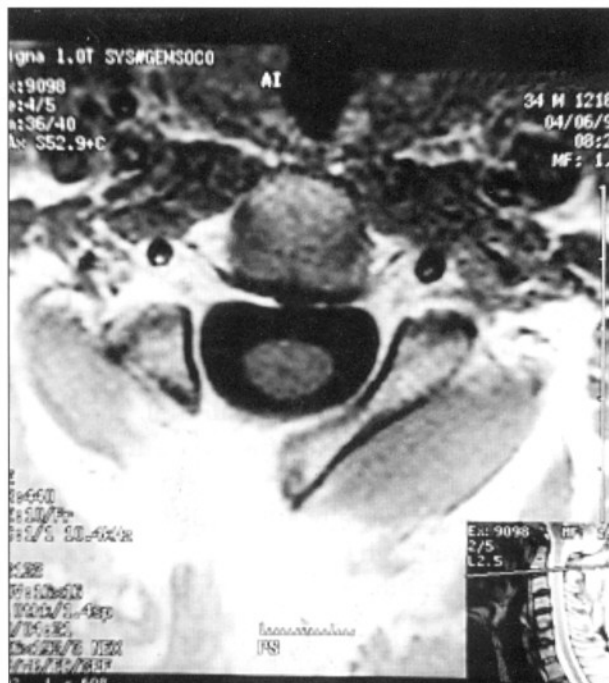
Post operative early gadolinium enhanced axial T1-weighted MRI demonstrates normal postoperative changes and no residual mass at the operation site.
